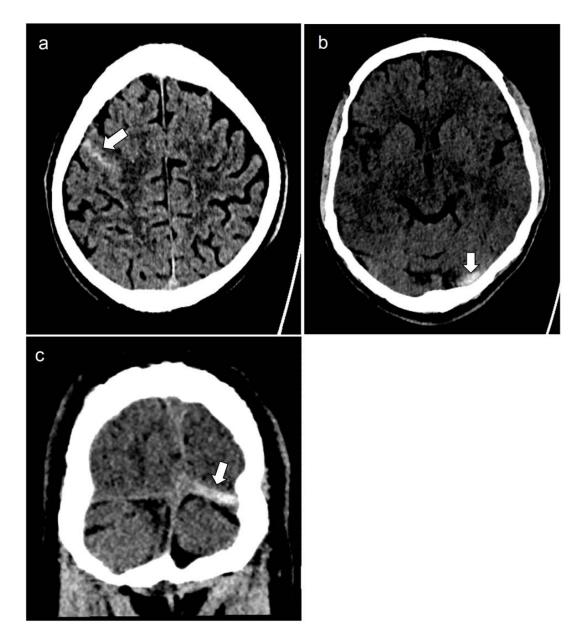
A, Unenhanced CT scan of head demonstrates subarachnoid hemorrhage in right frontal sulci (arrow). B, Unenhanced CT demonstrates hyperdense left transverse sinus (arrow). C, Coronal reformation of CT again demonstrates the hyperdense left transverse sinus (arrow).
